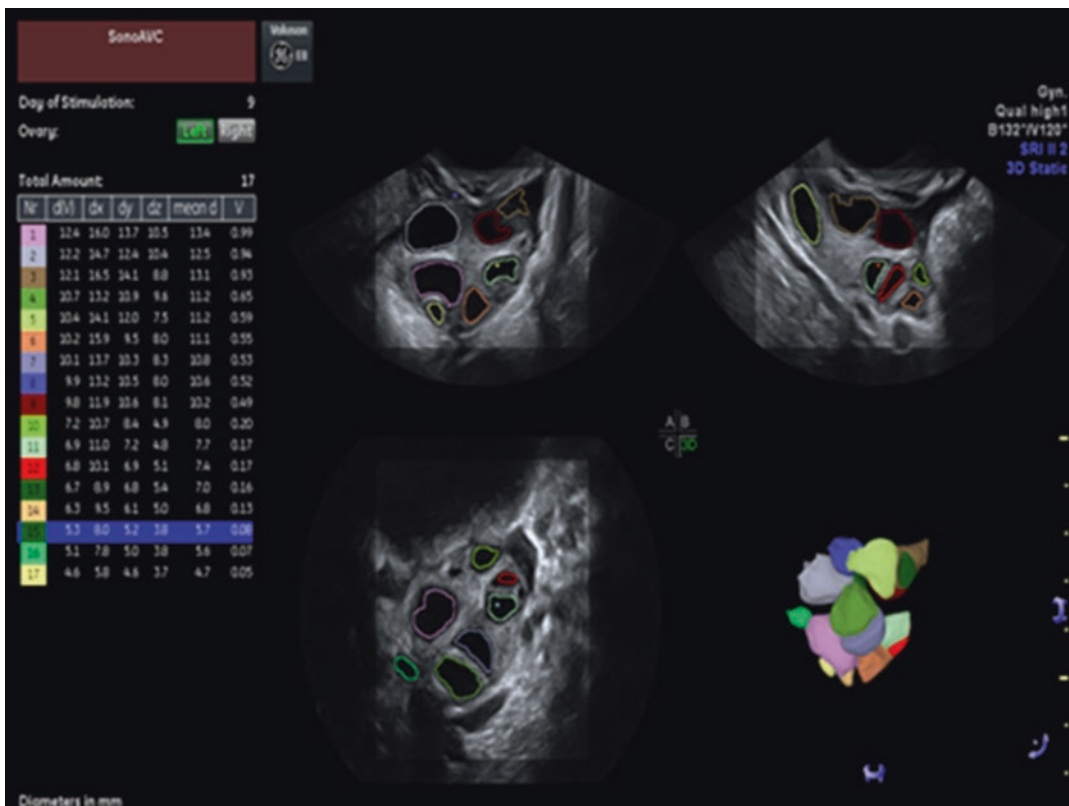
Sono AVC ultrasound study. Automatic estimation of diameter and volume. Each volume is separately color-coded (see text)
